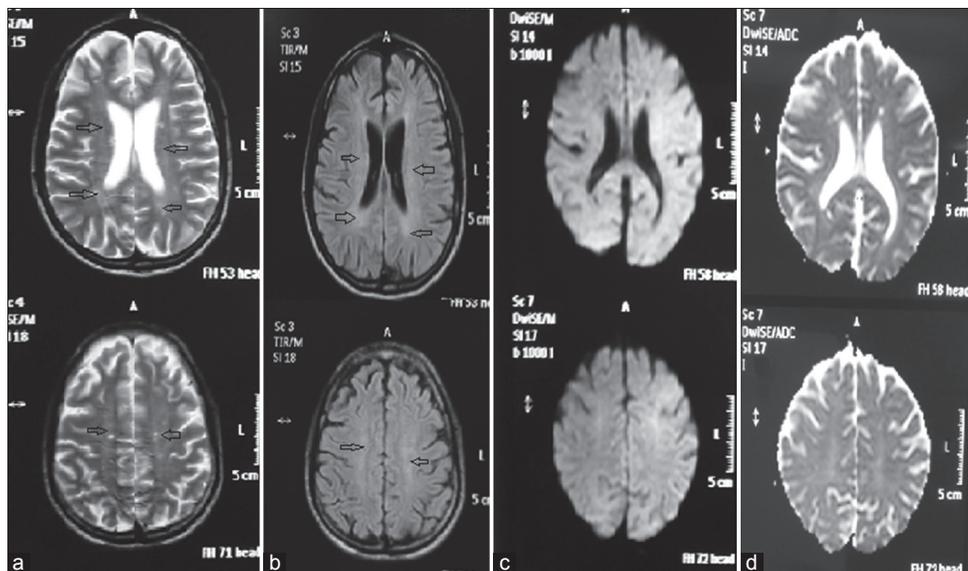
Follow-up magnetic resonance imaging at 6 months. (a) T2-weighted images show the resolution of lesions seen in previous magnetic resonance imaging with only mild confluent hyperintensities in perivascular regions. (b) Fluid-attenuated inversion recovery images show the resolution of lesions in previous magnetic resonance imaging. (c) Diffusion-weighted imaging images are normal and do not show restricted diffusion. (d) Normal apparent diffusion coefficient map images
